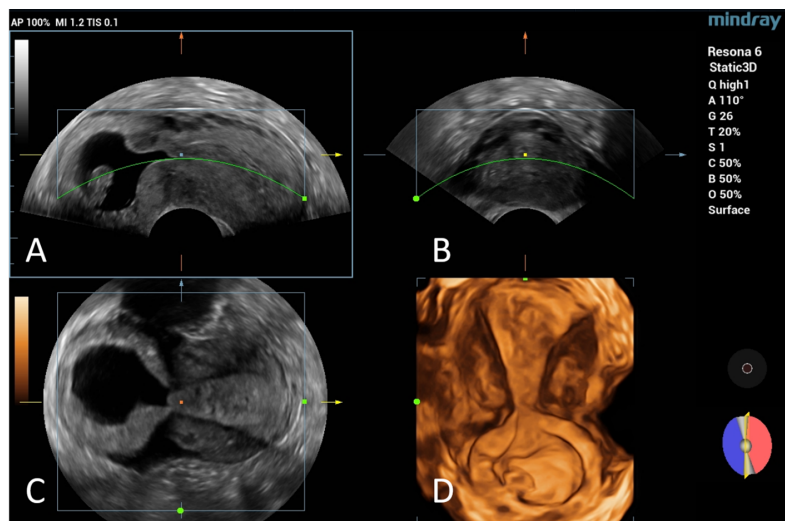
Three-dimensional ultrasound multiplanar reconstruction of cervical ectopic pregnancy demonstrating coronal sections (A, C) and longitudinal section (B) of the cervical pregnancy, providing comprehensive spatial orientation of the gestational sac within cervical tissue. Panel (D) shows a 3D surface rendering of the coronal section, clearly delineating the relationship between the gestational sac and cervical anatomy. The multiplanar approach confirms the gestational sac location below the internal os level and enhances diagnostic confidence.
